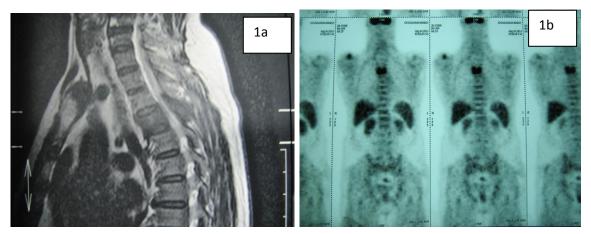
MRI cervical spine T2WI sagittal view shows diffuse T2WI hypointense signal involving body and posterior element of D3 vertebrae.1b: 99mTc bone scintigraph scan showing increased uptake of thoracic vertebrae
